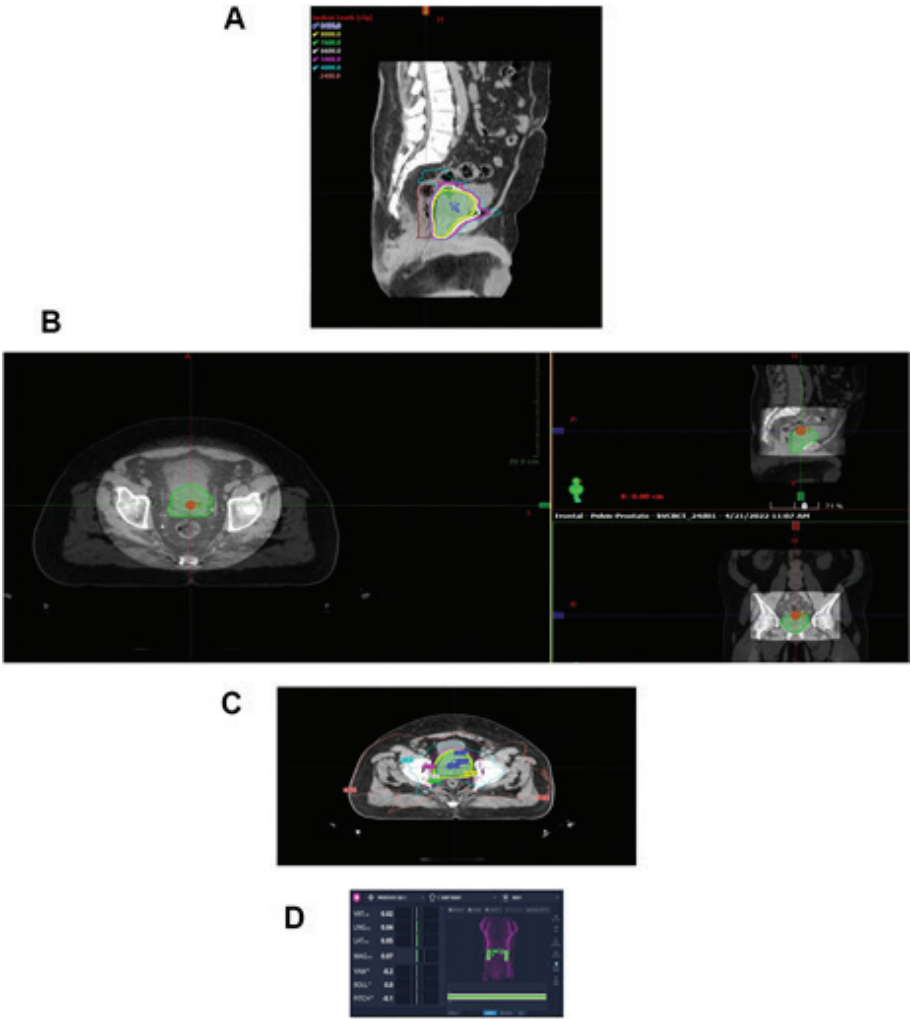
Process improvements in radiotherapy of prostate cancer. A, Dose gradients across bladder and rectum for a traditional radiation therapy using intensity modulation. Daily image guidance allows for adjustments in positioning each day relative to target motion. B, A cone beam computer tomography image obtained pre-therapy to validate target positioning on a daily basis. The security provided by image guidance permits titration in planning target volumes which in turn decrease dose to normal tissue further. The use of volume modulated arcs permits rapid therapy delivery over a few minutes giving confidence to both physicians and patients in limiting intrafraction motion of targets further promoting security in daily treatment execution. C, Arc geometries applied to prostate cancer care. Optical tracking provides both stability and security in daily positioning and monitors external motion during therapy. D, An example of optical tracking in a prostate cancer patient. Image courtesy of the Department of Radiation Oncology, UMass Chan Medical School and UMass Memorial Health.
